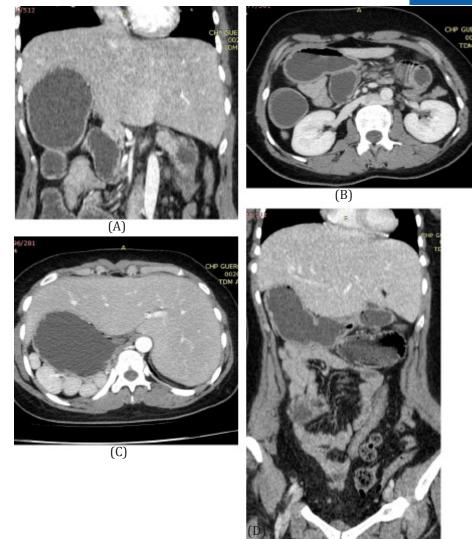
axial (B, C) and coronal (A, D) contrast- enhanced abdomino-pelvic CT demonstrated an interruption of inferior vena cava (A), abdominal situs inversus with polysplenia (B) and intestinal malrotation (C: IMV in the left of IMA, D: Small bowel in the right side and colon in the left side).
